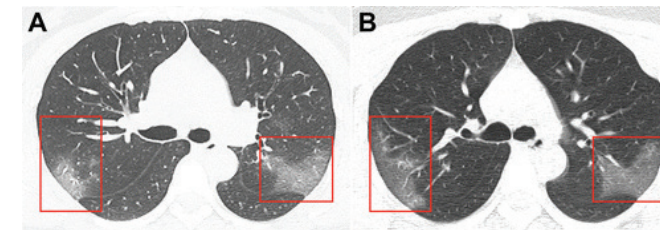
Image from Lei et al. CT Imaging of the 2019 Novel Coronavirus (2019-nCoV). Pneumonia
